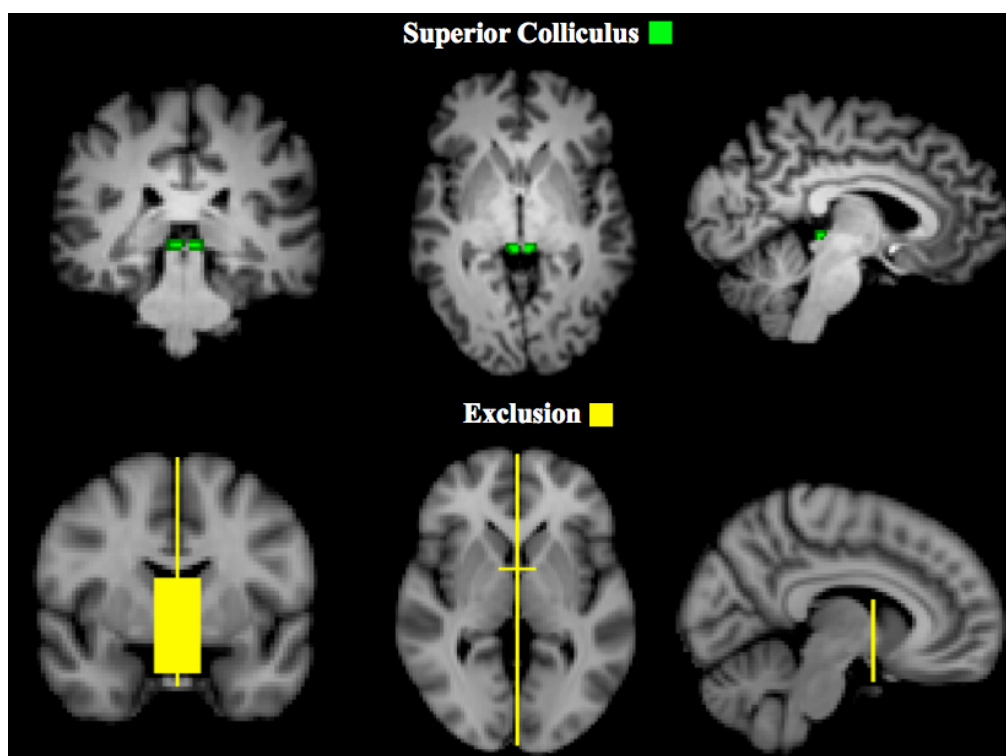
Masks used for the virtual dissection of connectivity between the superior colliculus (SC) and the amygdala. Left, coronal sections; middle, axial sections; right, sagittal sections. Superior colliculus masks are shown in green (top) in one representative participant. Exclusion masks are presented in yellow (bottom) on the Montreal Neurological Institute (MNI) T1-weighted standard atlas brain scan.
